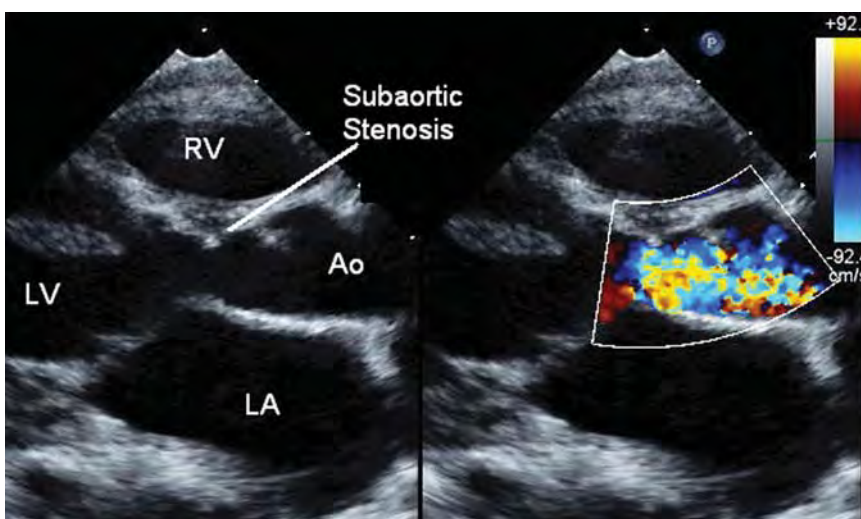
Parasternal long-axis view in color compare mode of a patient who has undergone repair of incomplete common atrioventricular valve. Within 1 year of surgery, the patient developed significant subaortic stenosis. Note the narrowing under the aorta and the color Doppler on the right panel which shows turbulent flow. The subaortic obstruction is from abnormal attachments of the left atrioventricular valve to the ventricular septum. Ao, aorta; LA, left atrium; LV, left ventricle; RV, right ventricle.
